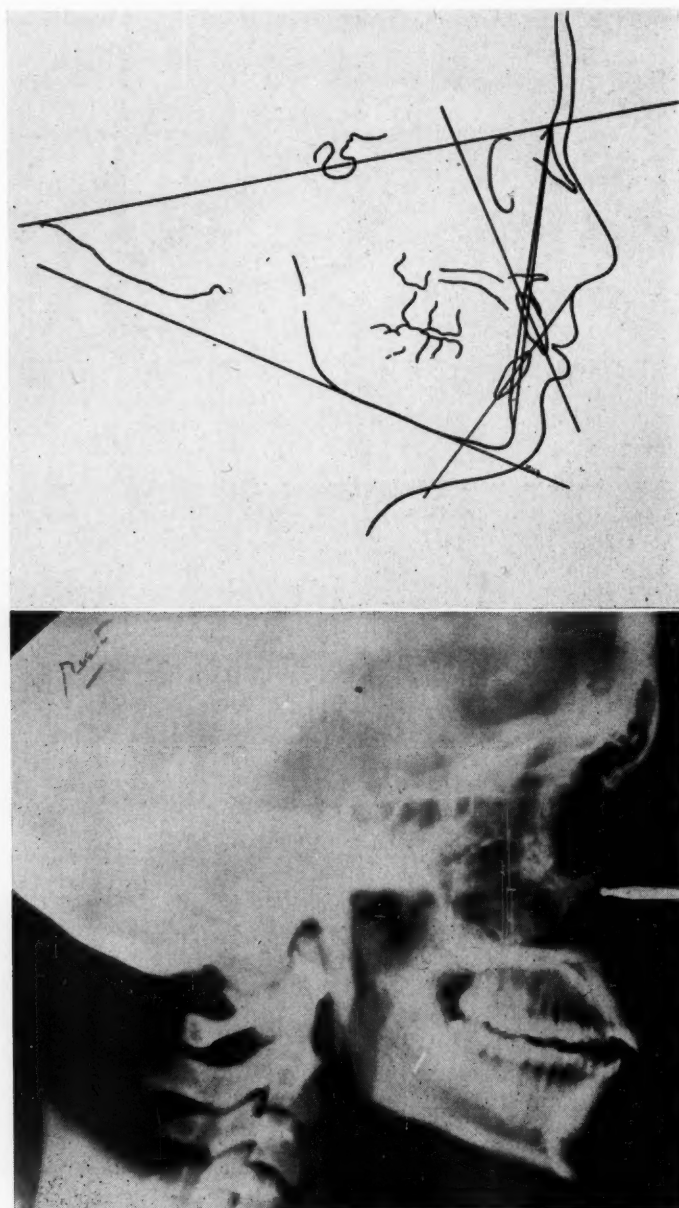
Patient J. H. Cephalometric radiograph and tracing in approximate centric occlusion.
